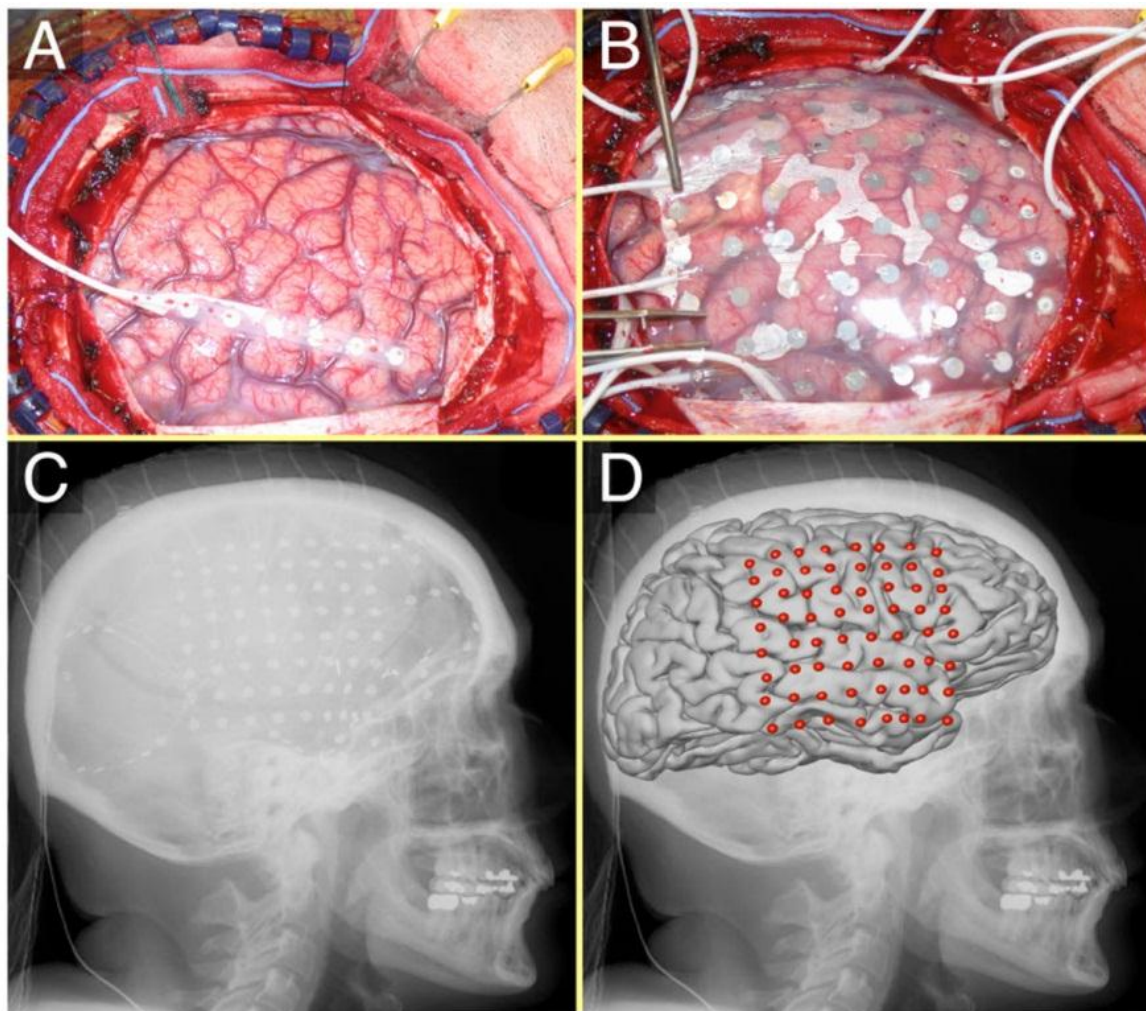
ECoG array in situ. A: Exposed brain after craniotomy. B: 8×8 electrode grid on the surface of the brain. C: Lateral x-ray image. The electrode grid and several strips are visible. D: Average brain template and electrode locations co-registered to the x-ray image. (Reproduced with permission (Schalk et al. 2008))
